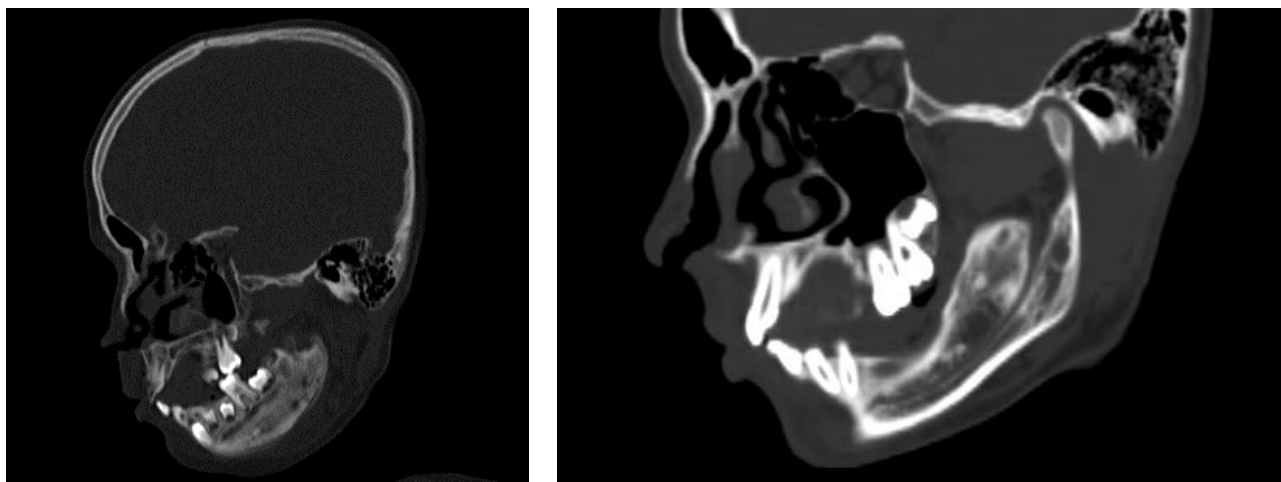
The nature of the position of the mandibular canal on the sagittal section of a native computed tomography study in 2 patients with fibrous dysplasia
